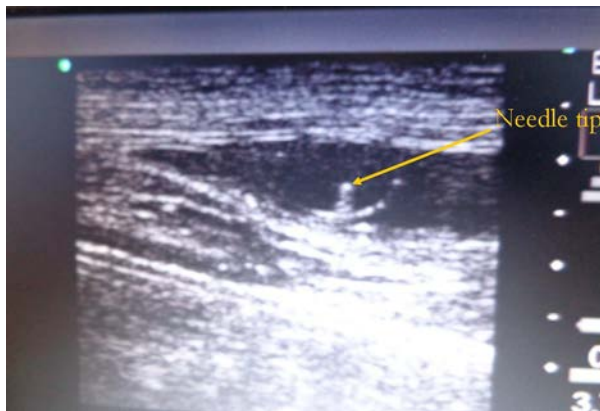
Ultrasound image of needle tip in out-of-plane approach.
